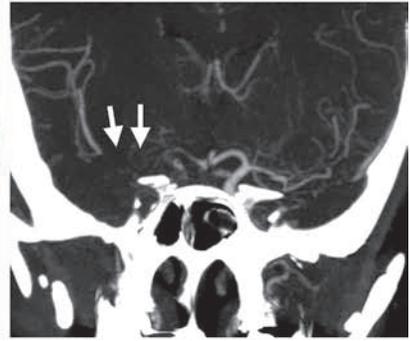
Acute stroke (2 hours evolution) in a 46-year-old man with left hemiparesis. (a) Nonenhanced CT scan shows slight hypoattenuation of the right basal ganglia. (b–e) Perfusion CT maps of MTT (b), CBF (c), and CBV (d) and a summary map (e) show 70% mismatch in the right frontotemporal region and basal ganglia. (f, g) Axial (f) and coronal (g) MIP reformatted CT angiographic images show obstruction of the right MCA (arrowheads in f) and right carotid artery (arrows in g). (h, i) Volume-rendered (h) and curved (i) reformatted images show significant stenosis of the right internal carotid artery (arrowheads). Thrombolysis was performed. (j) Follow-up nonenhanced CT scan obtained 24 hours later shows established infarction in the right basal ganglia only, related to the area observed on the CBV map (cf d).
